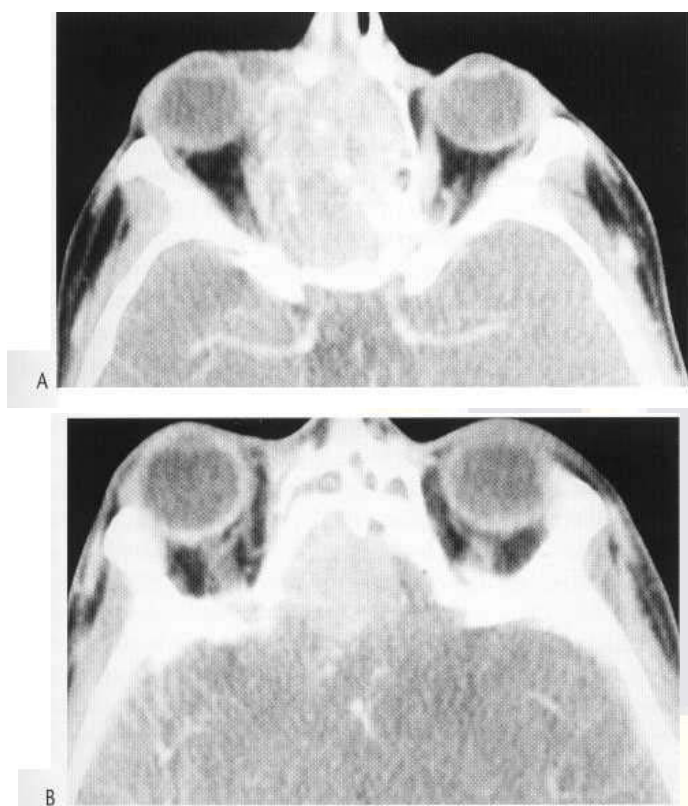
(A, B) Axial contrast-enhanced CT scans of an extensive ethmoid carcinoma showing abnormality extending up through the cribriform plate and involving the inferior aspect of the frontal lobes bilaterally (B).
